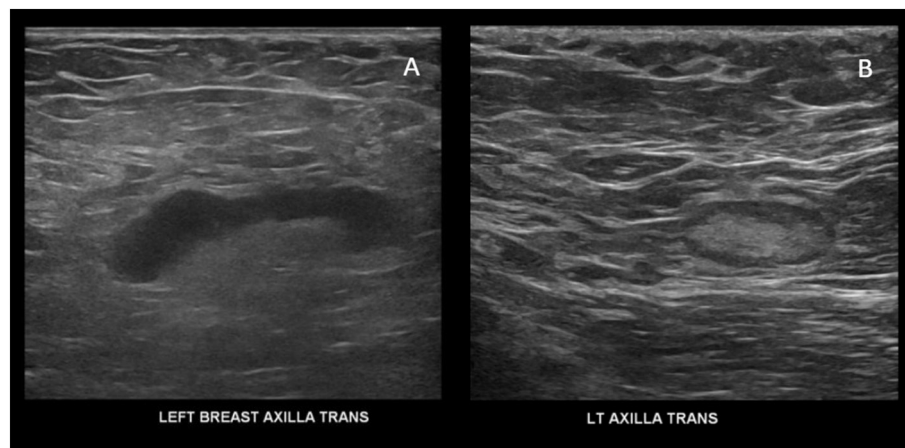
(A) Static ultrasound images of the left axilla from screening breast ultrasound demonstrated diffuse increased echogenicity axillary adipose tissue, and prominent lymph nodes with diffuse cortical thickening measuring up to 0.6 cm. (B) Static ultrasound image of the left axilla thirteen days later at the time of diagnostic imaging demonstrated complete resolution of the edema and lymphadenopathy.
